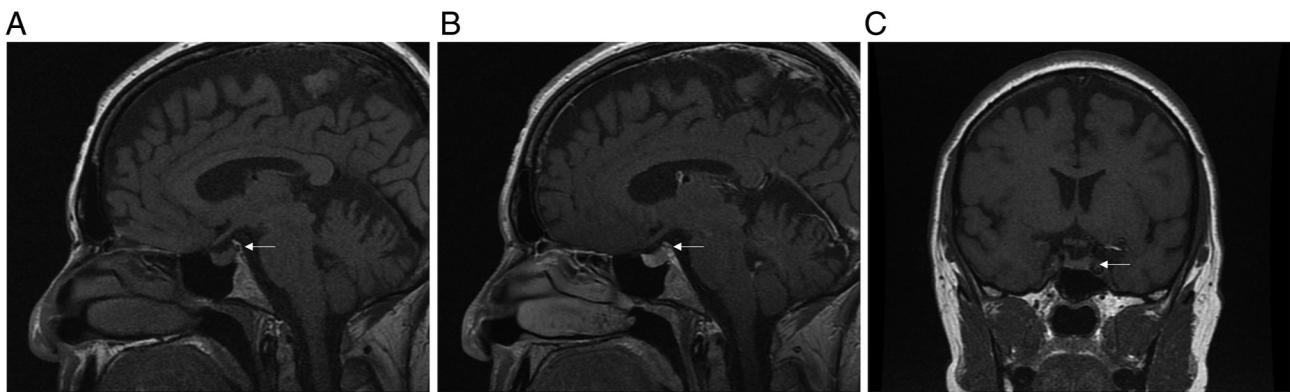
MRI of our patient's pituitary gland. (A) Non-contrast T1 sagittal sequence showing the absence of the bright spot of the posterior pituitary gland (white arrow). (B) Post-contrast T1 sagittal sequence showing a normal posterior pituitary gland (white arrow). (C) Pre-contrast T1 coronal sequence showing a normal posterior pituitary gland (white arrow).
